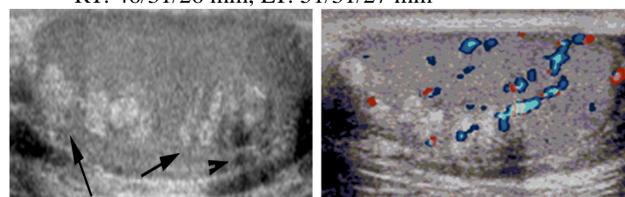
Ultrasound of the left testis showed multiple hyperechoic nodular lesions (arrows) in the mediastinum of the testes
